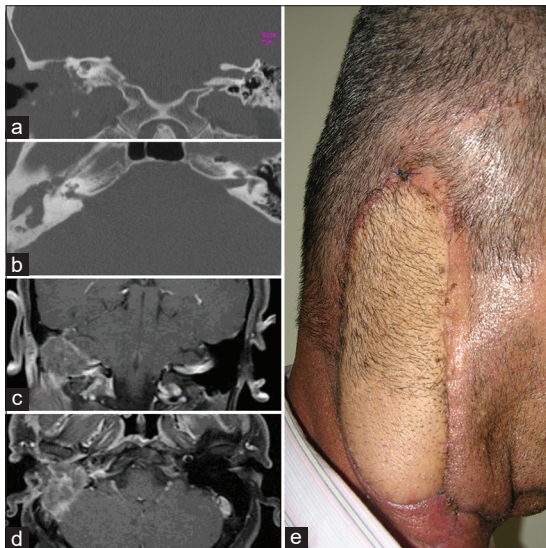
The patient with primary carcinoma of the right temporal bone. He had tympanoplasty before due to chronic otitis media. Temporal bone tomography on coronal (a) and axial (b) demonstrates irregular destruction of the mastoid bone. MRI on coronal (c) and axial (d) view confirm the mass occupying lesion in the right mastoid. The patient had lateral temporal bone resection with the removal of the parotid gland and the facial nerve. The nerve was reanimated with hypoglossal-facial anastomosis. Pectoralis regional flap was used to cover the defect (e)
